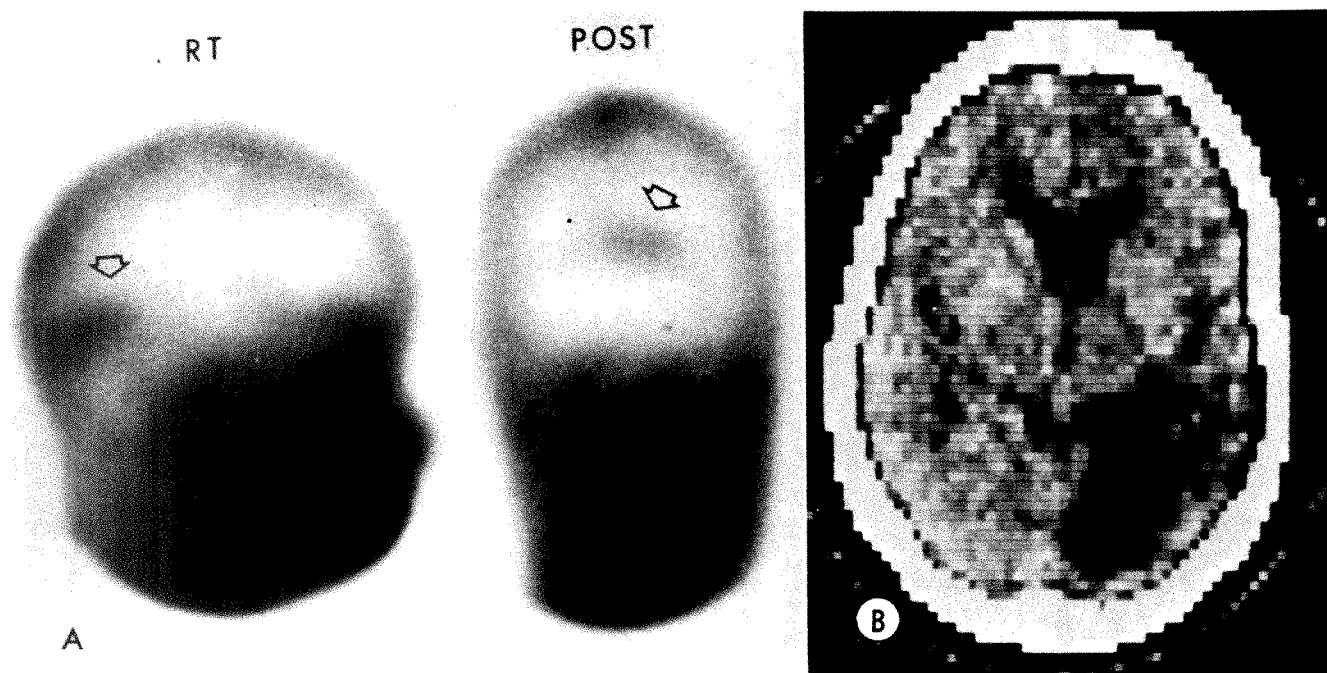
54-year-old man with sudden onset of left homonymous hemianopia 12 days before; occlusion of right posterior cerebral artery proved by angiography. *A*, Static radionuclide scan showing area of increased uptake just right of midline on posterior view. On lateral view, wedge-shaped increased uptake extends down to confluence of sinuses and is adjacent to transverse sinus (positive tentorial confluence sign). *B*, CT scan showing sizeable area of decreased density in right occipital lobe.
